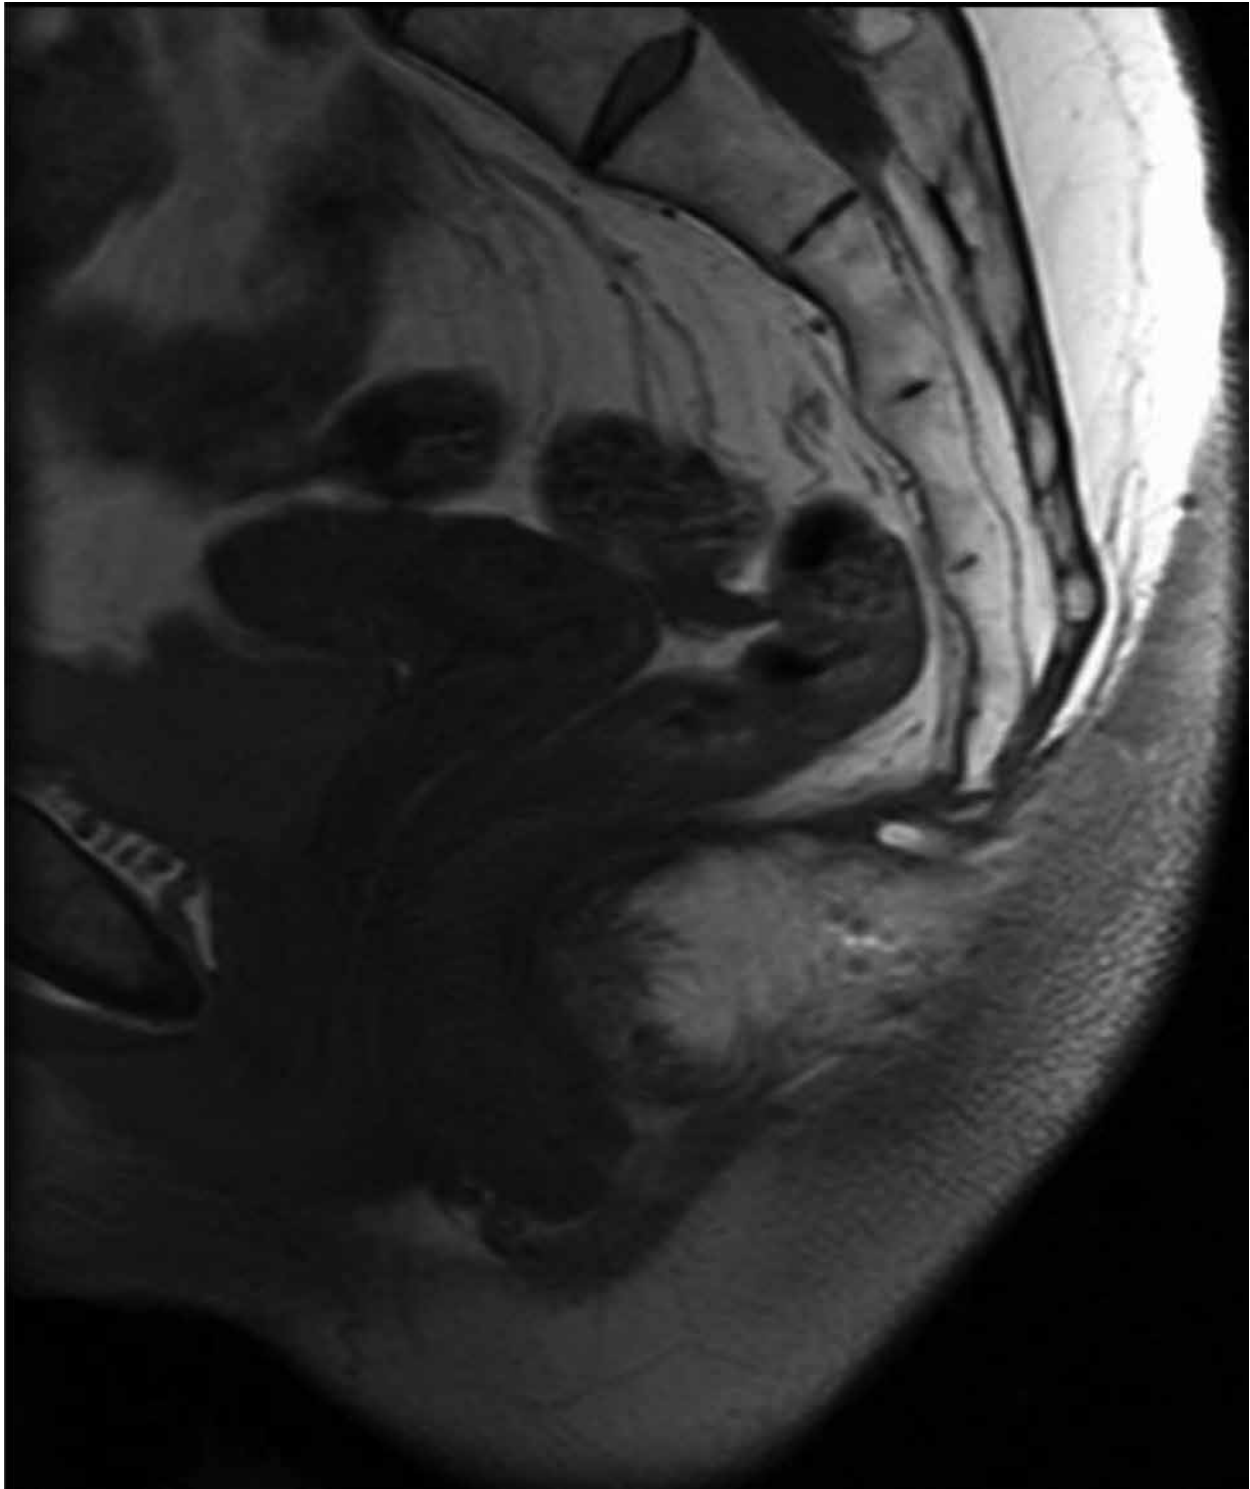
MRI pelvis post-coccygectomy, 2007. Sagittal view. No residual mass is identified in the pelvic space. There is some mild edema and enhancement in the region which may be related to postsurgical change. There is absence of the coccygeal segments.
